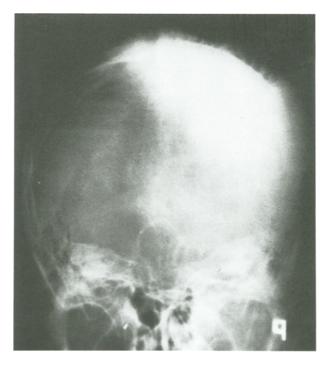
Plain skull X-ray reveals hyperostosis of the calvarium, located mainly on the right side with radial striations of the diploic trabeculae
